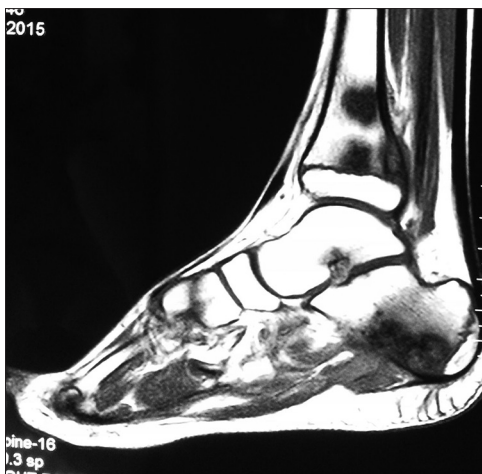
MRI T2W sagittal image showing multiple osteolytic lesions in tibia, calcaneum and talus
